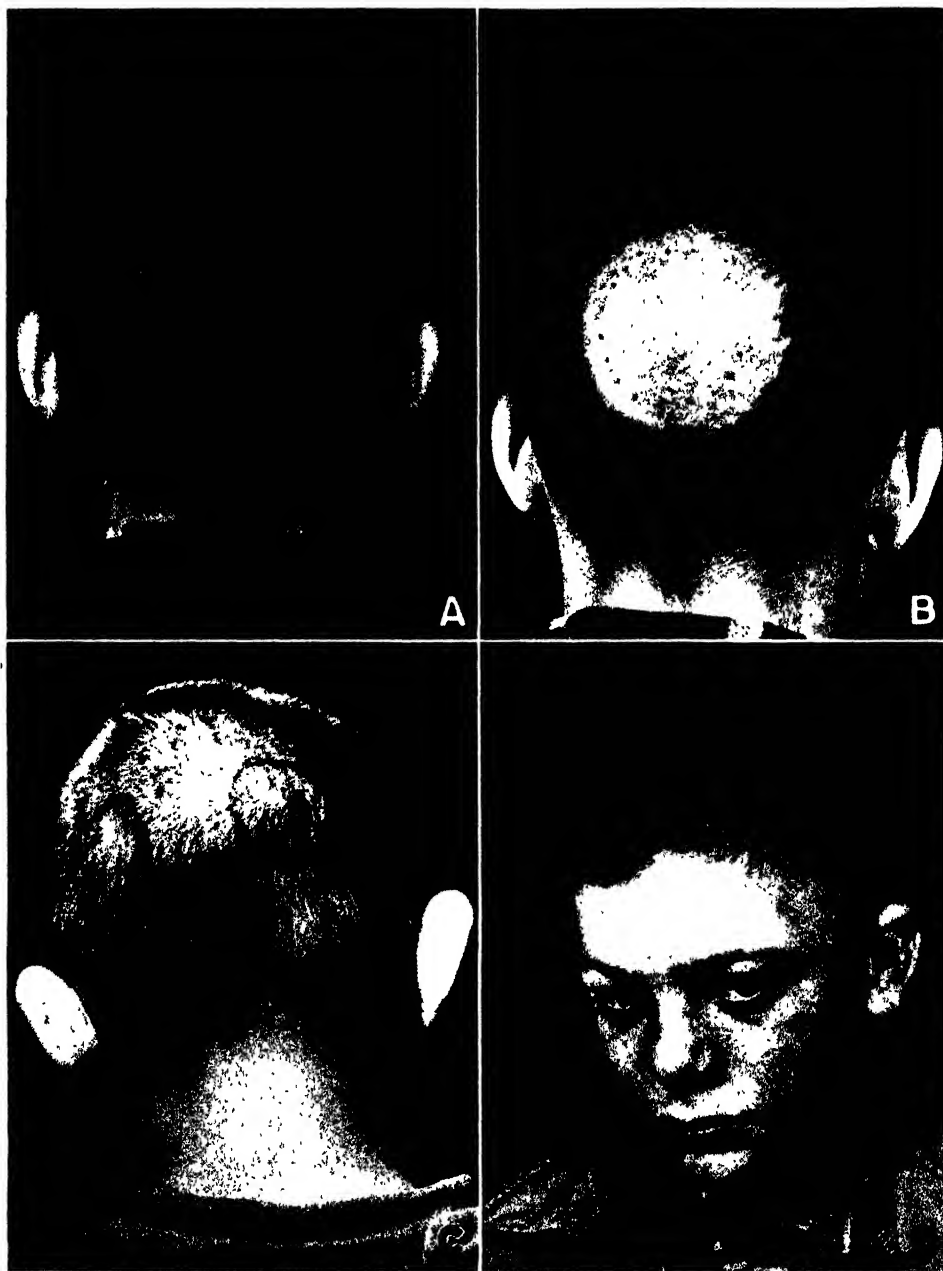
Tinea capitis (*M. audouini*) of limited extent and recent origin treated successfully with x-rays to the localized infection. Careful attention to detail is necessary (see text). A and B, before and after preparation for treatment. C, two obscure lesions in occipital region outlined to reveal extent of fluorescent hairs. D, small localized lesion over left temple following epilation.
